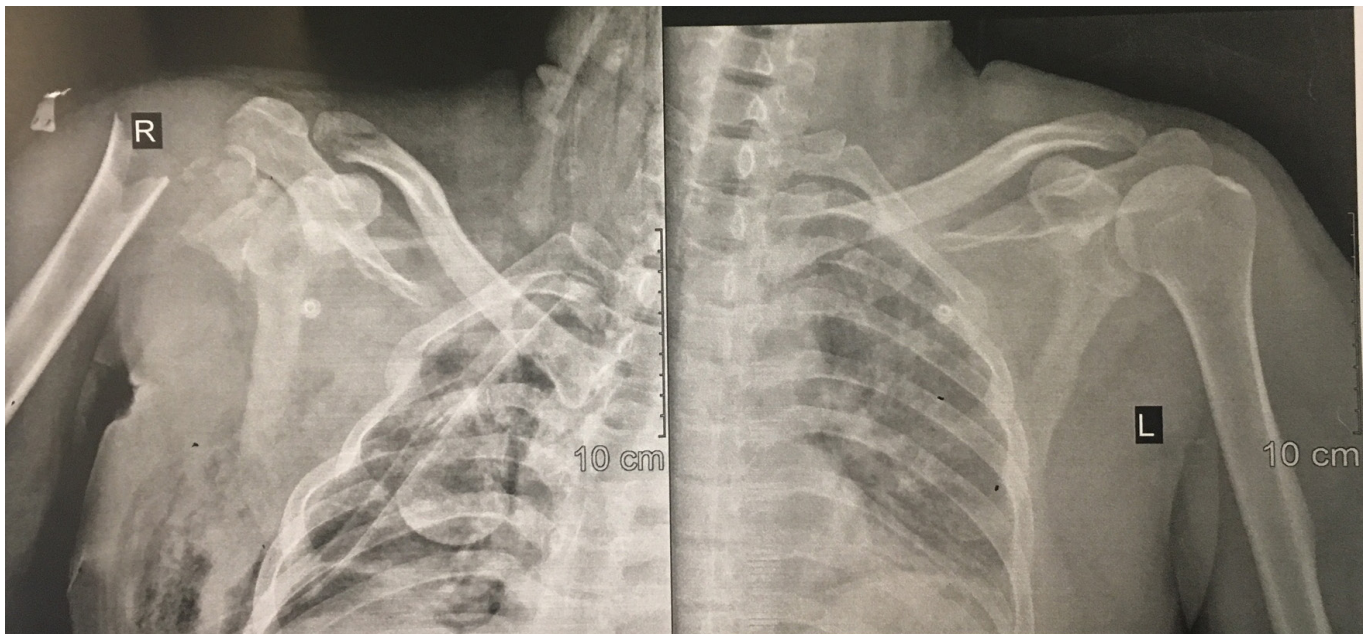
Chest radiography shows forearm dislocation and fracture of Humeral head, glenoid, acromion and posterior arch of 3rd, 4th and 5th ribs. Right chest-tube and head of humerus are seen in right hemi-thorax.
